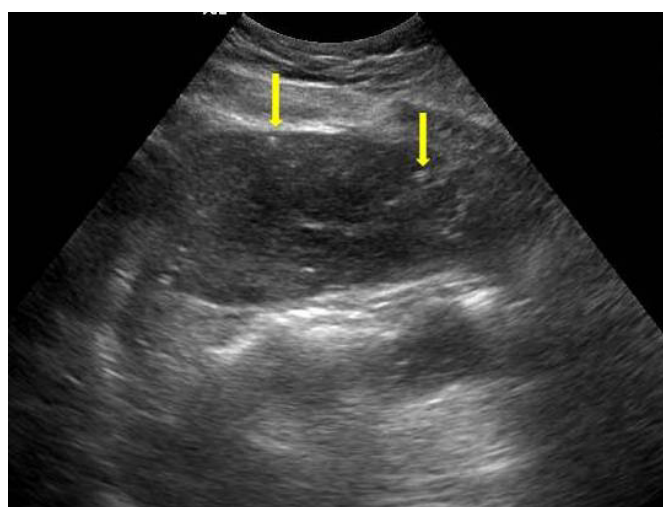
Transverse ultrasound image of the abdomen showing a heterogeneous hypoechoic lesion (arrow) with geographic distribution in the left lobe of liver with small peripheral echogenic foci
